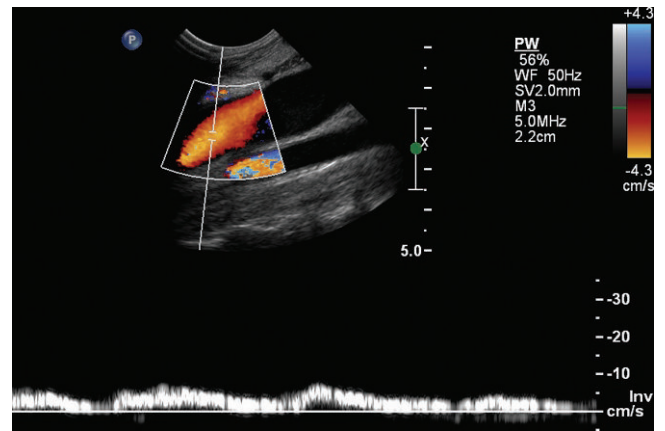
Spectral Doppler of internal jugular vein confirms the retrograde direction of flow. The waveform is above the baseline because the spectrum is inverted.
